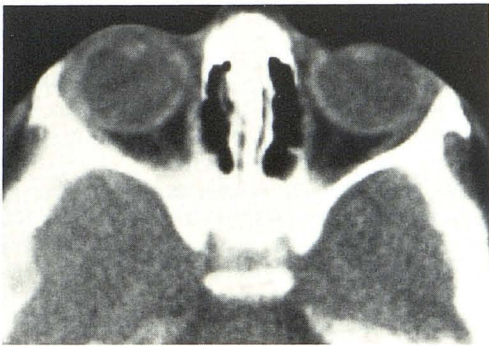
Axial orbital CT scan. Unusually small optic nerves.
